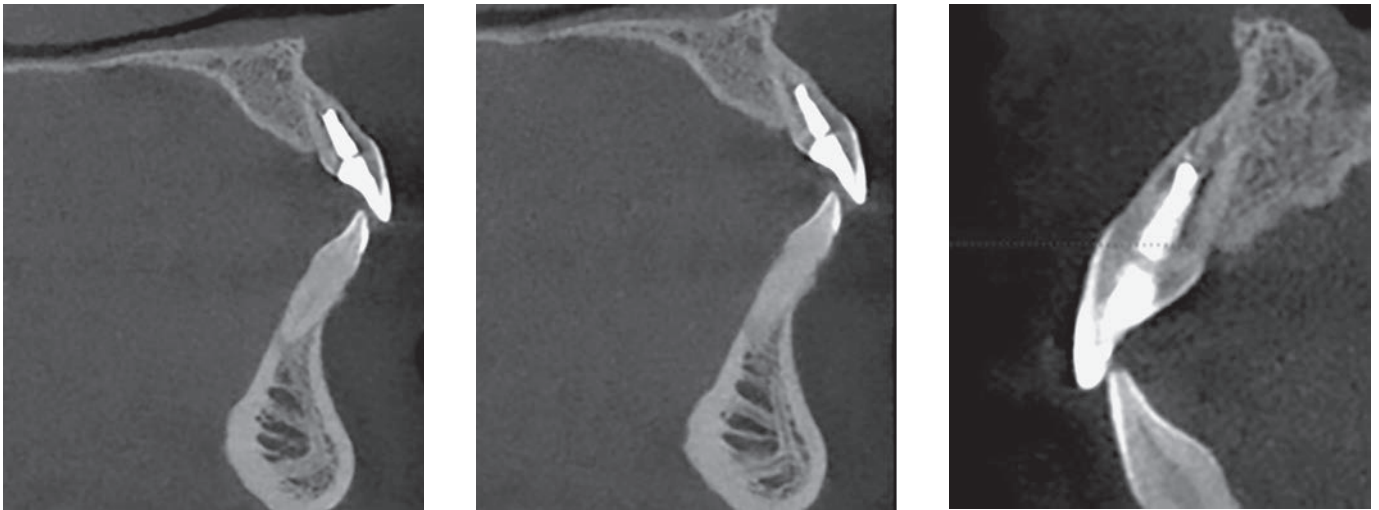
Cone Beam Sagittal sections, July 2015.
